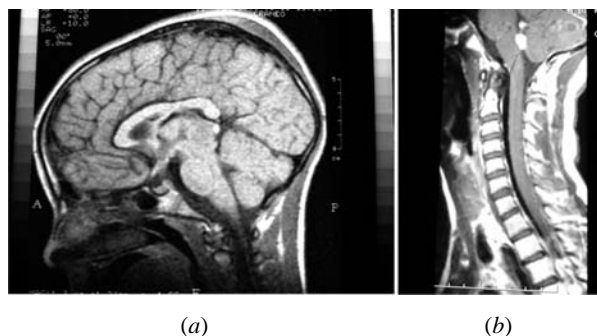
Germinoma MRI imaging. (a) MRI brain sagittal section showing germinoma in pineal region (arrow). (b) Hyperintense mass lesions suggestive of germinoma metastases (arrow) in fourth ventricle.
